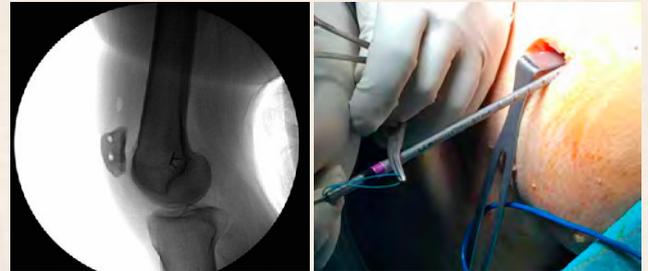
Two tunnels were made in the proximal half of the medial patella edge (x-ray intraoperatively). 2b. Over the medial epicondyle the tunnel for the femoral insertion of the MPFL was also opened.
